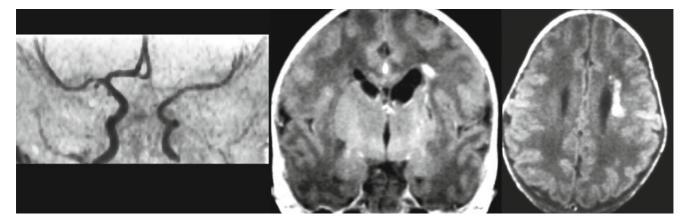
Absence of the left ACA A1 part, attenuated left MCA and ipsilateral periventricular injury, in a term infant with one episode of neonatal convulsions (*left* MRA, *middle* coronal and *right* axial T1 MRI)
